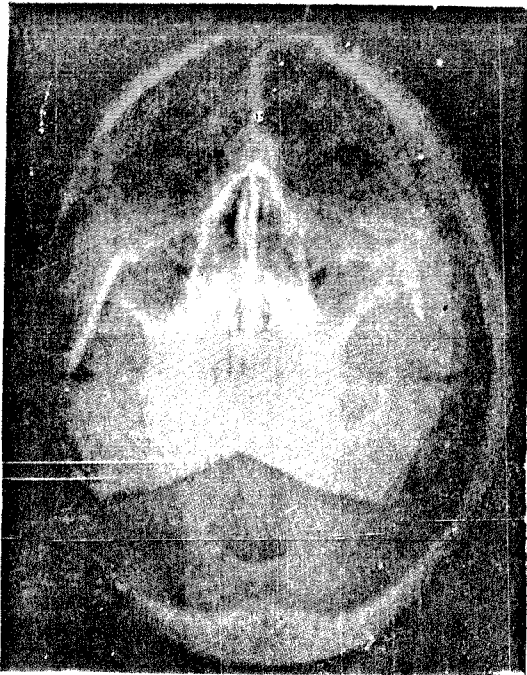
X-ray showing contrast media in the right transferred duct.
